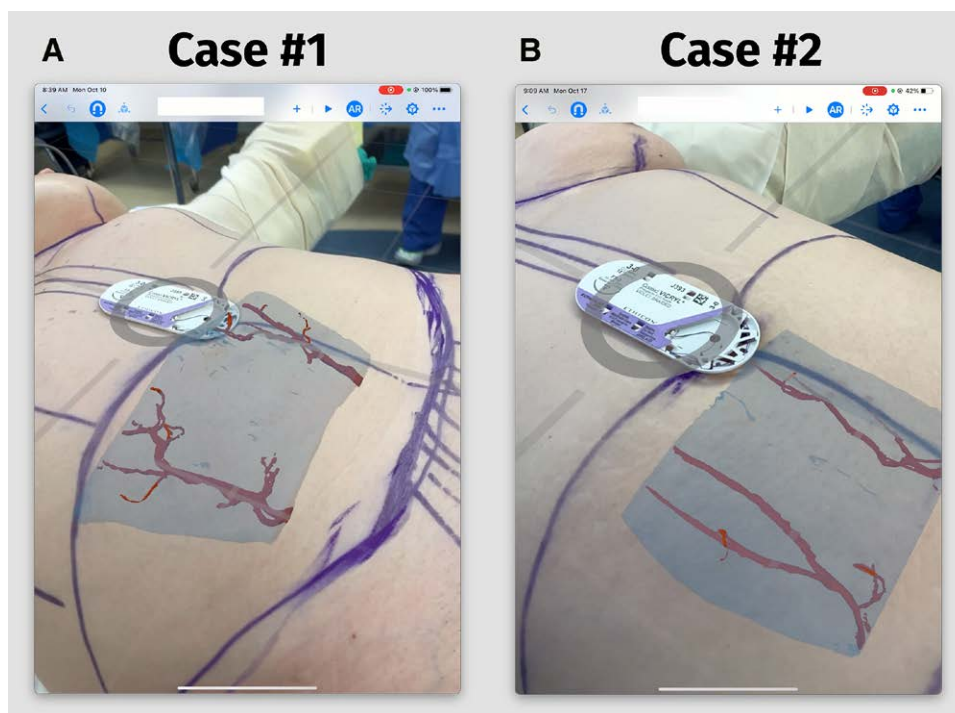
Demonstration of two intraoperative cases. A, Anterior-posterior view of AR model aligned to suture pack placed above the umbilicus. B, Tracking in space when moved right caudally. Muscle is displayed at accurate depth (as extracted from CTA). Of note, only parts of the rectus muscle and DIEA are modeled and displayed.
